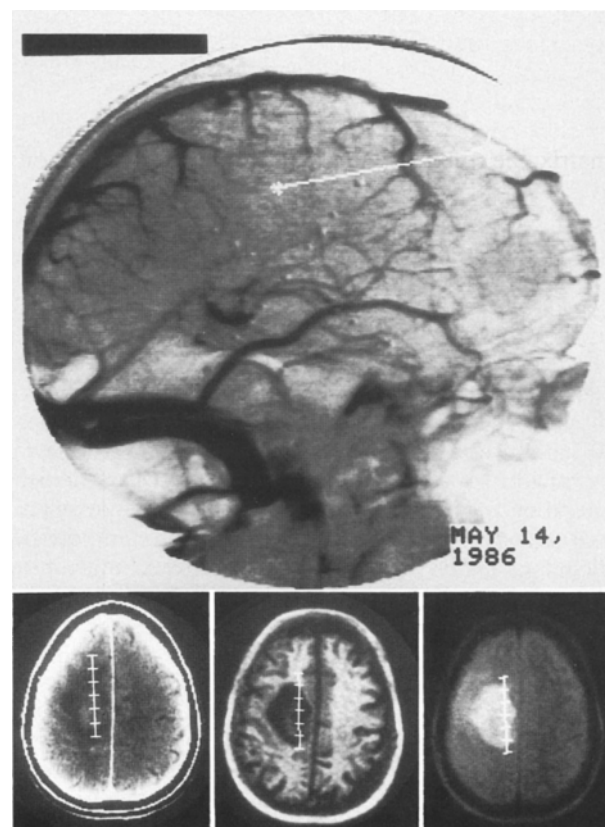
Upper:* Display of biopsy trajectory on a venous digital angiogram. Note the 18 reference marks created by the angiographic reference system. *Lower:* The position of each intended 1-cm biopsy along the selected trajectory is indicated between each horizontal mark on the stereotaxic computerized tomography slice (*left*) and on the T_1 -weighted (*center*) and T_2 -weighted (*right*) magnetic resonance images.
